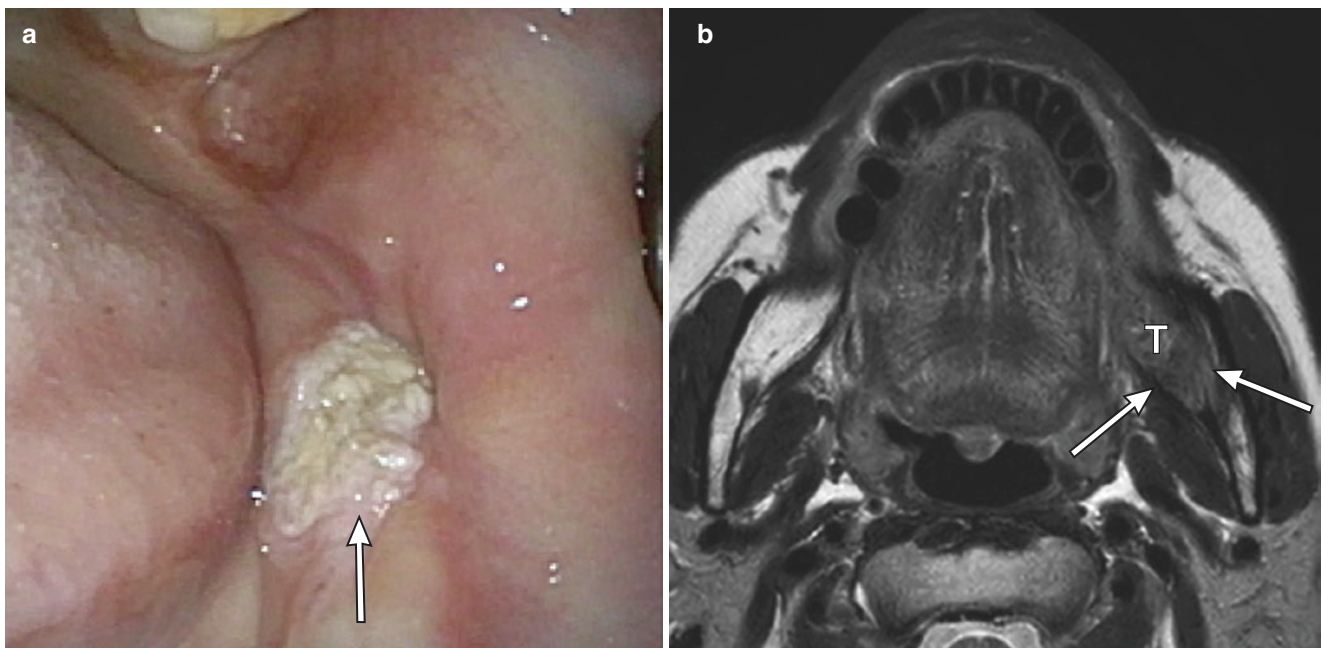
A 71-year-old woman with squamous cell carcinoma of the retromolar area. (a) The tumor (T) is located at left retromolar area. (b) T2-weighted image shows tumor invading the mandibular ramus (arrow), which is not detected in the intraoral findings
